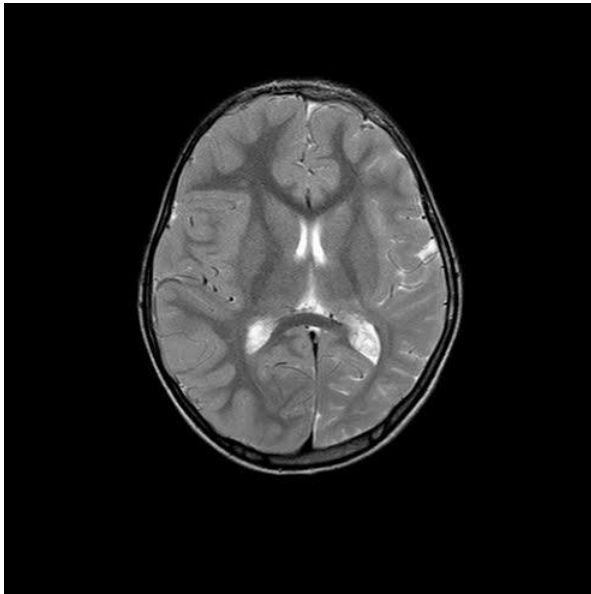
MRI brain with left sided atrophy with gyral calcification.
